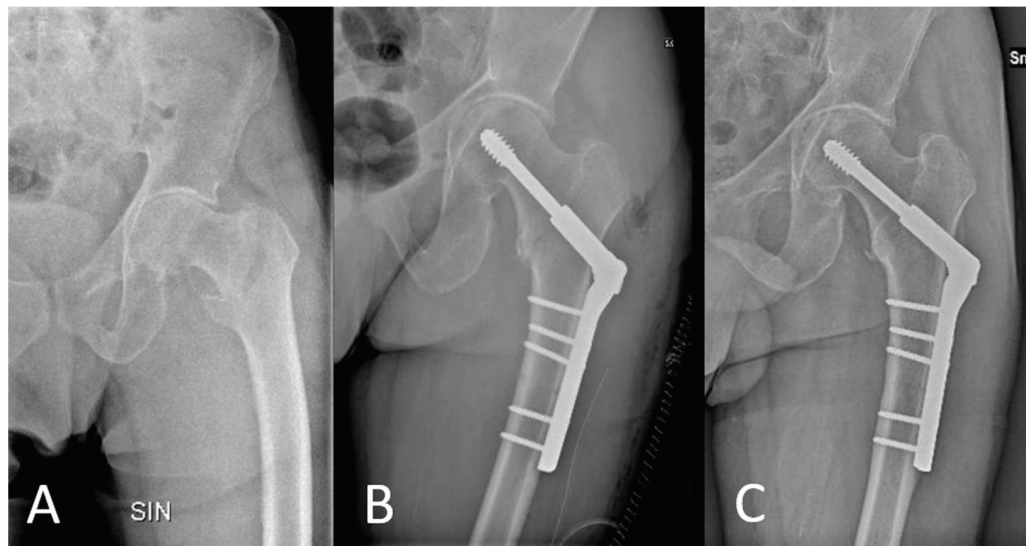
X-ray assessments at the time of trauma (A), immediately post-operatively (B), and at the final follow-up (C).
